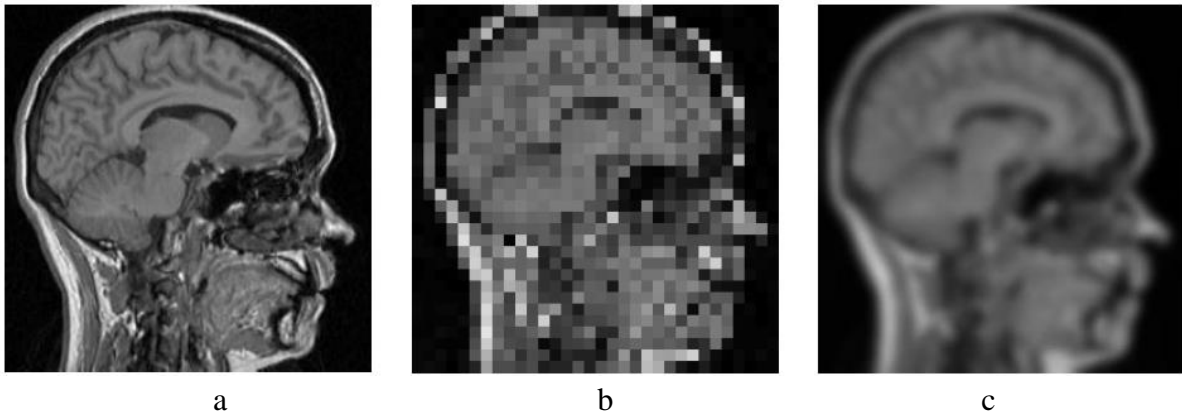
a) is an MRI of head that is convolved with a squared aperture shown in (b) and with a Gaussian filter in (c). [272]
